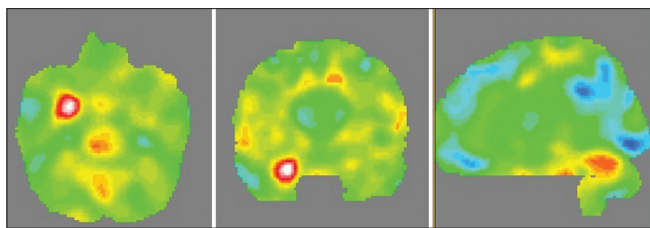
Separate brain F-18 fluorodeoxyglucose positron emission tomography/computed tomography images (scenium siemens software) show hypermetabolism in bilateral basal ganglia, hippocampus, amygdala, and mesial temporal lobe (right > left) (red and white color indicates hypermetabolism, blue indicates hypometabolism, green indicates normal metabolism)
